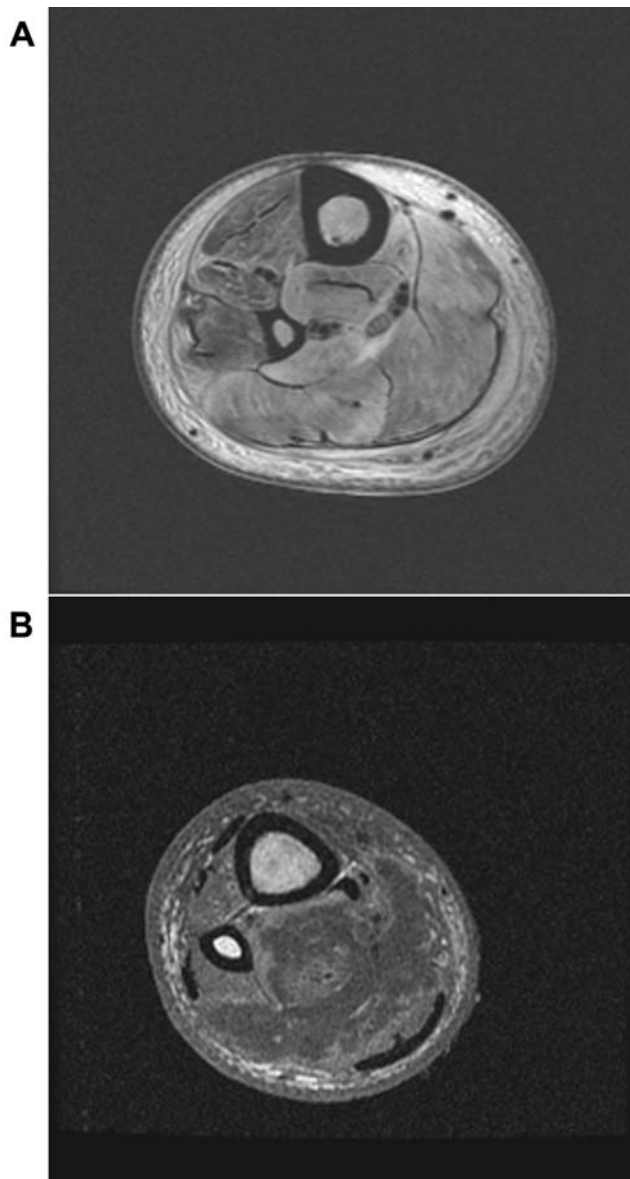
Magnetic resonance images showing pyomyositis cases without and with abscess formation. *A*, Axial T2-weighted spin-echo magnetic resonance image showing edema of the leg muscles. *B*, T1-weighted magnetic resonance image showing a large irregular abscess confined in the posterior compartment of the calf with surrounding edema.
